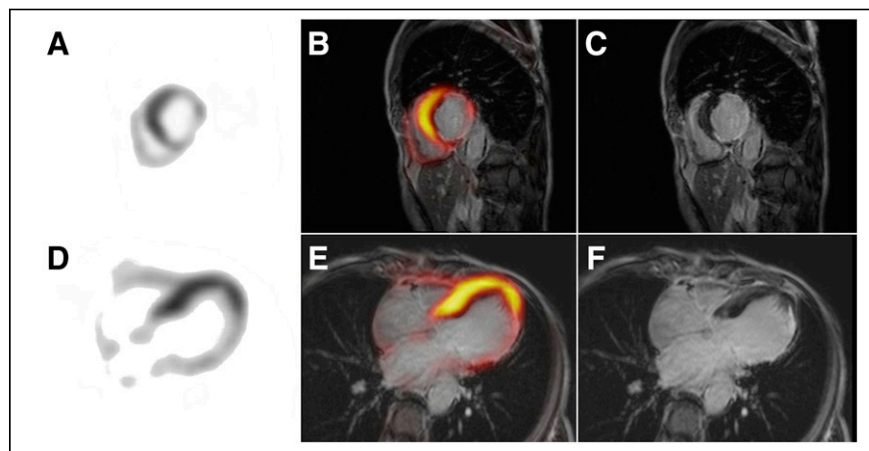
Patient with left ventricular ejection fraction of 30% and inferior-to-posterolateral akinesia on echocardiography. ^{18}F -FDG PET/MRI shows decreased metabolic activity of posterolateral wall (A and D), corresponding to late gadolinium enhancement on MR images (C and F) and confirmed on fused images (B and E). (Reprinted from (31).)
